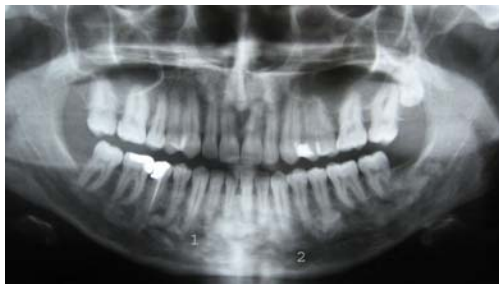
Panoramic radiograph showing changes in radiodensity at the postoperative 3rd year.
